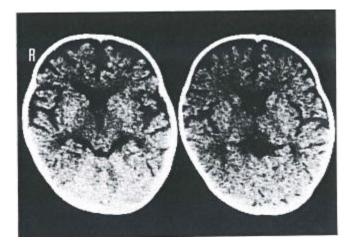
In the CT scans taken on October 14, there are no visible areas of low density, but there is an indication of widened spaces in the subarachnoid area of the brain.
